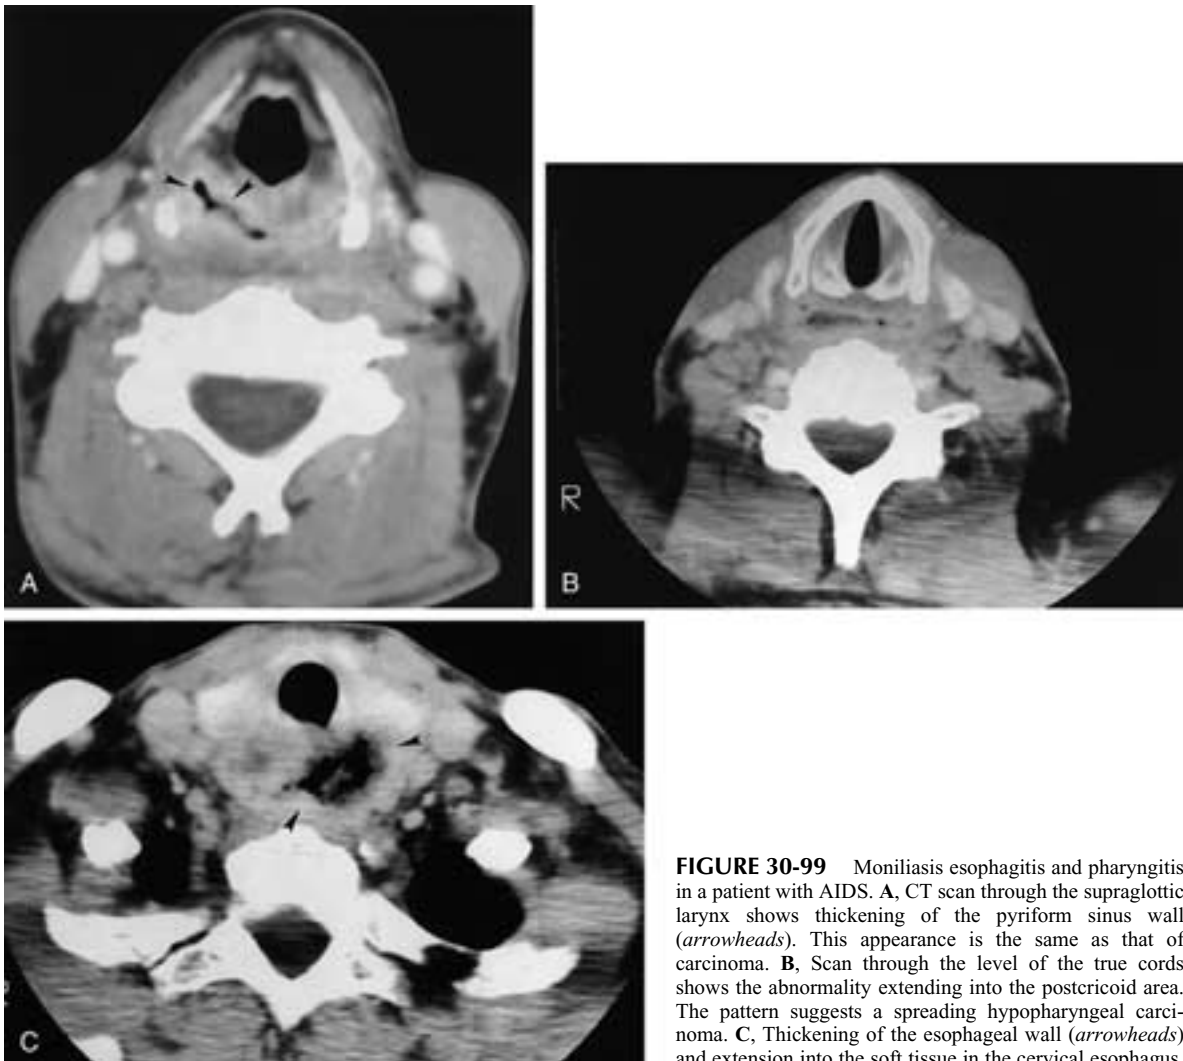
Moniliasis esophagitis and pharyngitis in a patient with AIDS. A, CT scan through the supraglottic larynx shows thickening of the pyriform sinus wall (arrowheads). This appearance is the same as that of carcinoma. B, Scan through the level of the true cords shows the abnormality extending into the postcricoid area. The pattern suggests a spreading hypopharyngeal carcinoma. C, Thickening of the esophageal wall (arrowheads) and extension into the soft tissue in the cervical esophagus.
